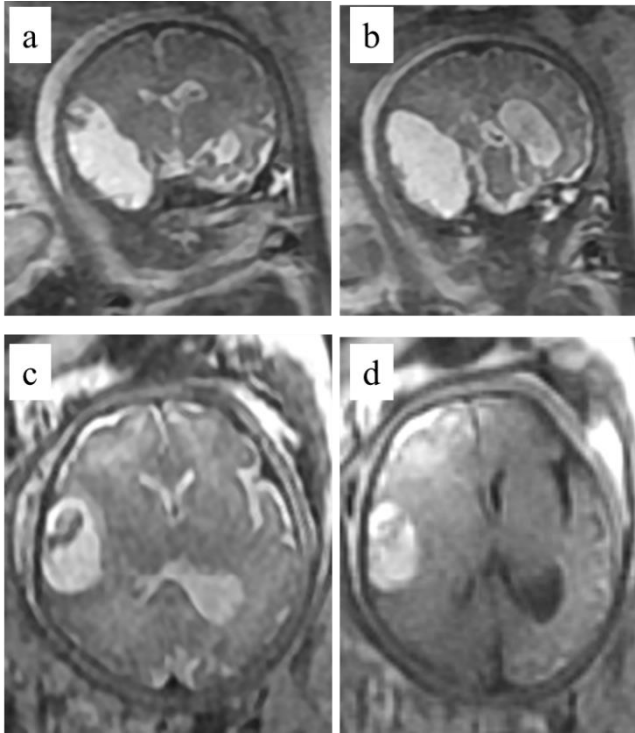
Haemorrhagic stroke. Coronal (3a and 3b) T2-weighted images of a 35gw fetus shows a large area of focal cystic encephalomalacia centres on the right temporal lobe and extending into the frontal lobe. The cavity has irregular margins and evidence of subacute haematoma (3c and 3d). There is mass effect with effacement of the ipsilateral lateral ventricle, midline shift and contra-lateral ventriculomegaly, probably secondary to hydrocephalus. A subsequent diagnosis of feto-maternal alloimmune thrombocytopenia was made.
